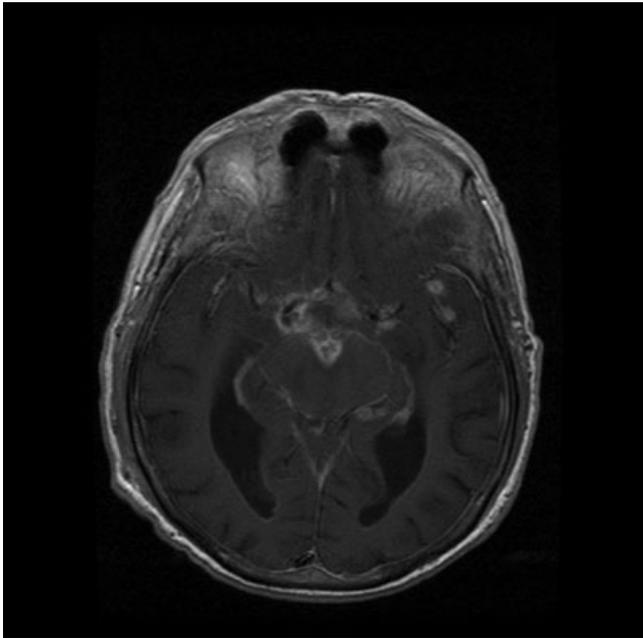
T1-weighted magnetic resonance imaging at symptomatic worsening, showing marked meningeal and cerebral trunk enhancement.
